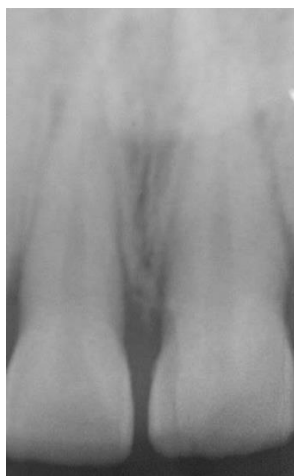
Radiographically, it is possible to observe that the interdental bone pick was intact.*
